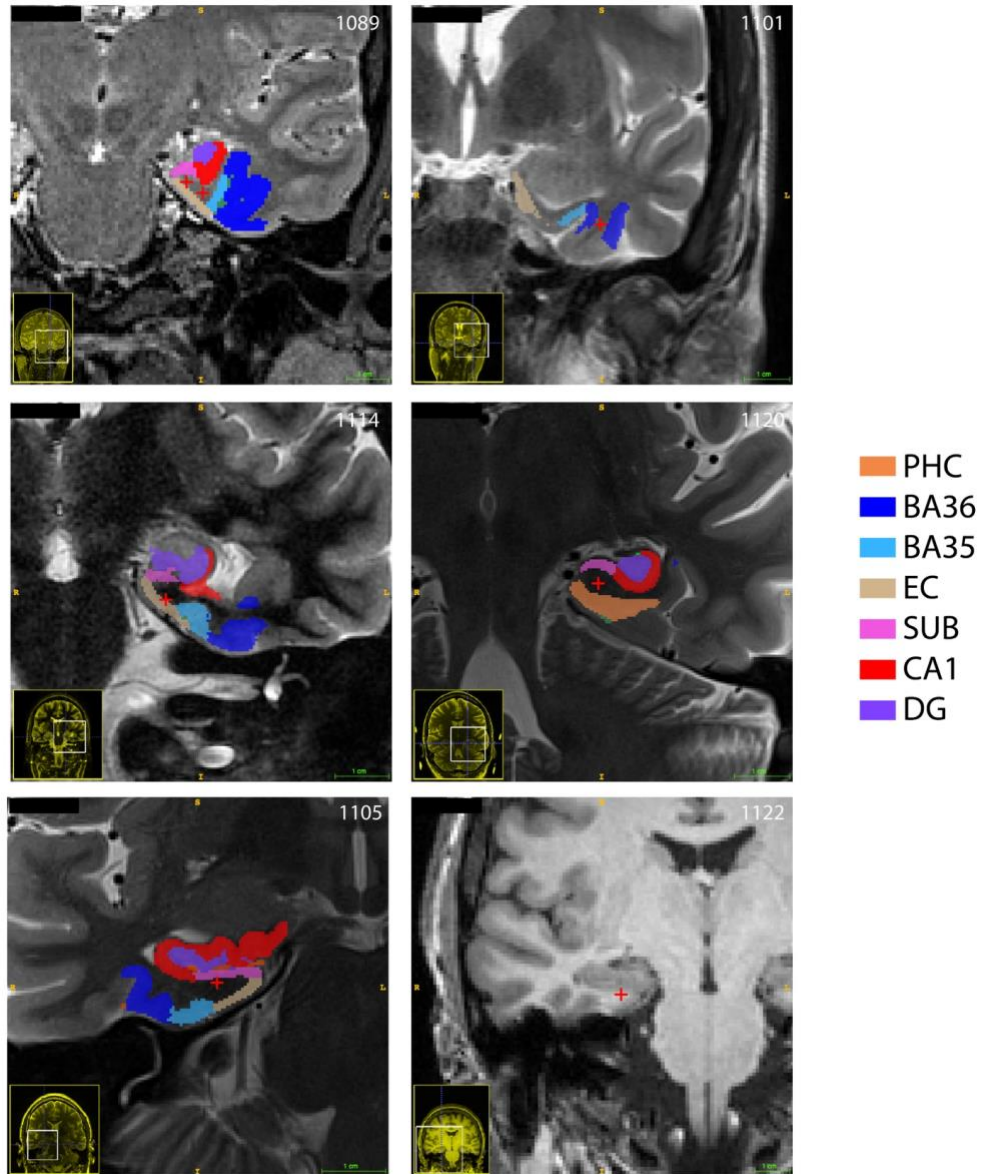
S1. MRI and electrode placements in white matter. In 6 subjects (7 distinct stimulation sites), bipolar stimulation electrode midpoints fell directly in MTL white matter, indicated by red crosses at the midpoint of the anode/cathode contacts. Overlaid segmentations show MTL subregions, according to the color legend above (no segmentation available for subject 1122). PHC, parahippocampal cortex; BA36, Broadmann area 36; BA35, Broadmann area 35/perirhinal cortex; EC, entorhinal cortex; SUB, subiculum; DG, dentate gyrus.
